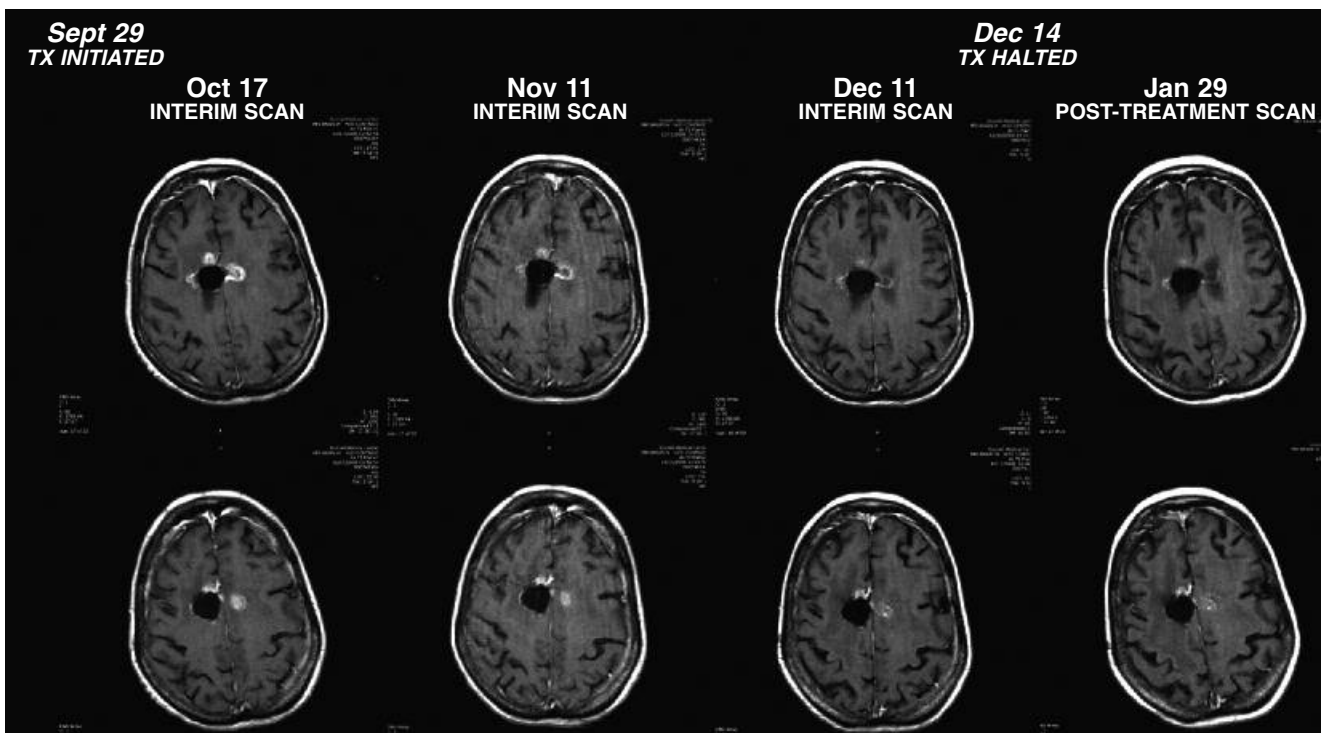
T1-weighted axial post-contrast images are presented for each date shown (2 adjacent slices each date), demonstrating a decrease in the intensity of the post-contrast signal, representing regression of gross recurrent disease.
